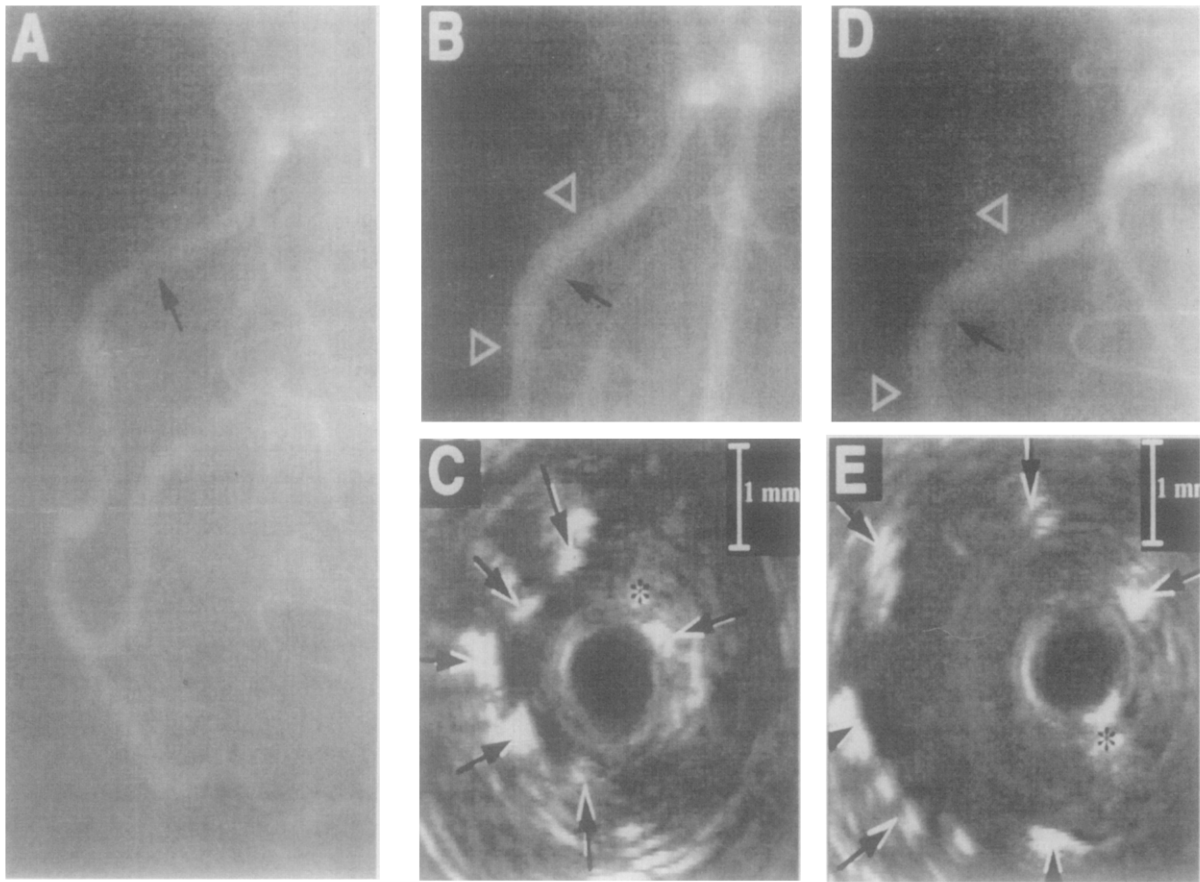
Role of intracoronary ultrasonography in stent deployment. A, Predilation angiogram with high-grade stenosis in proximal right coronary artery (*arrow*). B, Angiogram after dilation of Palmaz-Schatz stent (*white triangles*) with 3.5 mm noncompliant balloon inflated to 10 atm. *Black arrow* denotes slight indentation in stent. C, Intravascular ultrasound image obtained at site of *black arrow* in B shows underexpanded stent with cross-sectional area of 3.1 mm.² Stent struts are demarcated by *black* and *white arrows* and guide wire with *asterisk*. D, Angiogram after final dilation of stent (*between white triangles*) with 3.5 mm noncompliant balloon inflated to 15 atm reveals minimal angiographic improvement. E, Subsequent intravascular ultrasound image recorded from same site (*black arrow* in D). Palmaz-Schatz stent struts are well visualized (*black* and *white arrows*), and stent is now well expanded, with intrastent cross-sectional area of 9.3 mm.² (From Colombo A, et al. Intracoronary stenting without anticoagulation accomplished with intravascular ultrasound guidance. *Circulation* 1995;91:6:1864.
